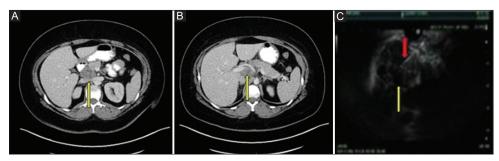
Retroperitoneal mass: (A) oral phase; (B) venous phase; (C) EUS-FNB. Yellow arrow: mass. Red arrow: FNB needle EUS, endoscopic ultrasound; FNB, fine-needle biopsy
